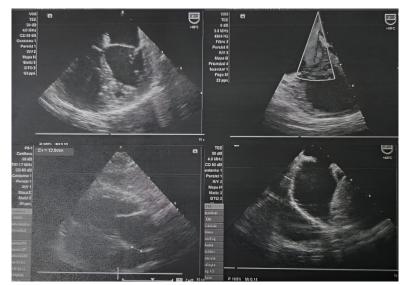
Transesophageal echocardiogram. Interatrial *septum* with orifice measuring 22 mm, with wide right-to-left shunt, *osteum secundum* type. Tricuspid valve with wide regurgitation jet that goes to the interatrial *septum* and reaches the septal defect
